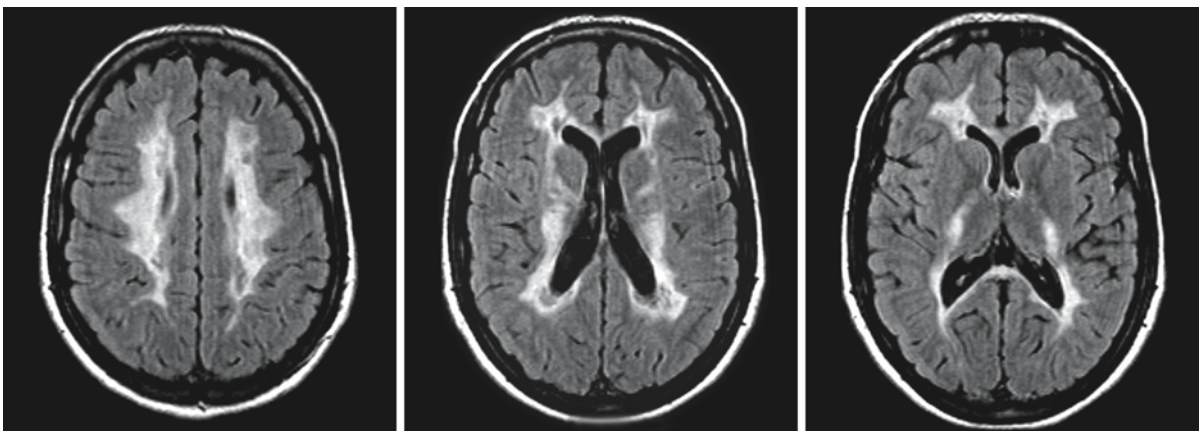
FLAIR images of the patient shown in Figs. 68.2–68.4. These images show that the abnormal white matter is inhomogeneous with areas of lower signal, suggesting focal white matter rarefaction
